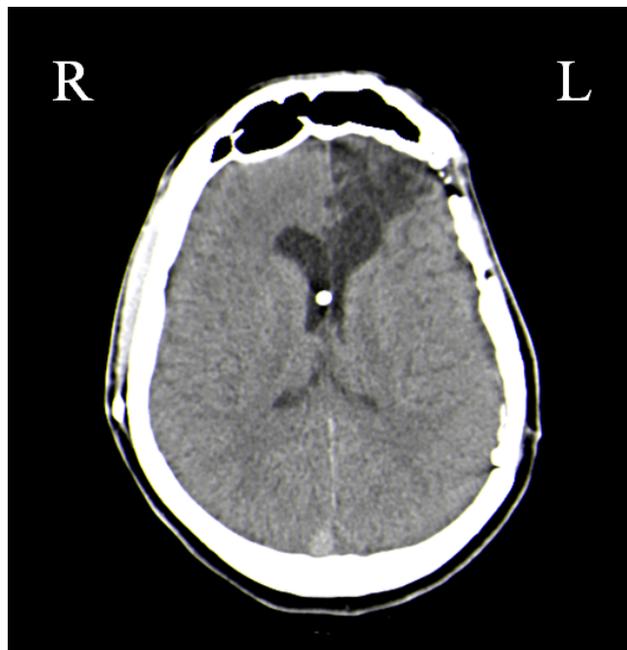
CT-scan showing left fronto-basal to fronto-polar damage.
